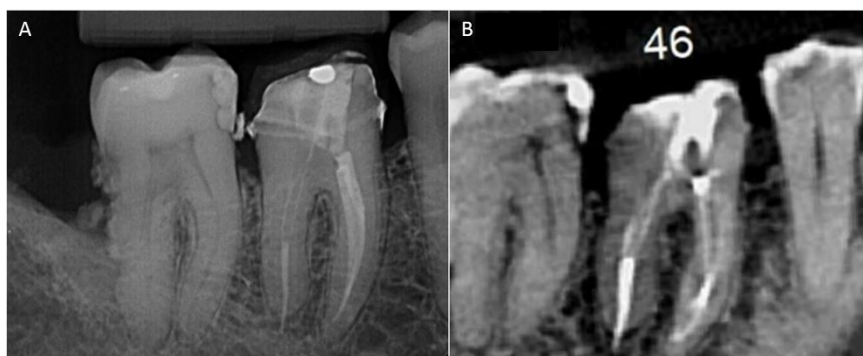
(A) Periapical radiography of tooth 46 with signs of filling material extravasation in the distal root canal and the presence of a fiberglass post. (B) CBCT examination showing the presence of periapical lesion and filling material extravasation.
